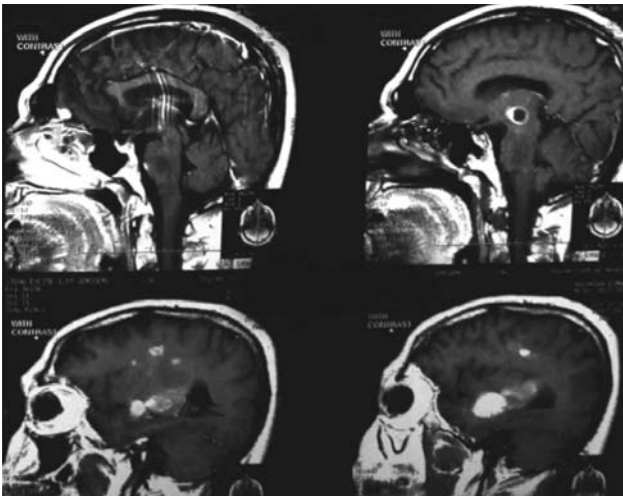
Sagittal brain MRI T1 images with gadolinium contrast administration showing multiple enhancing lesions.
